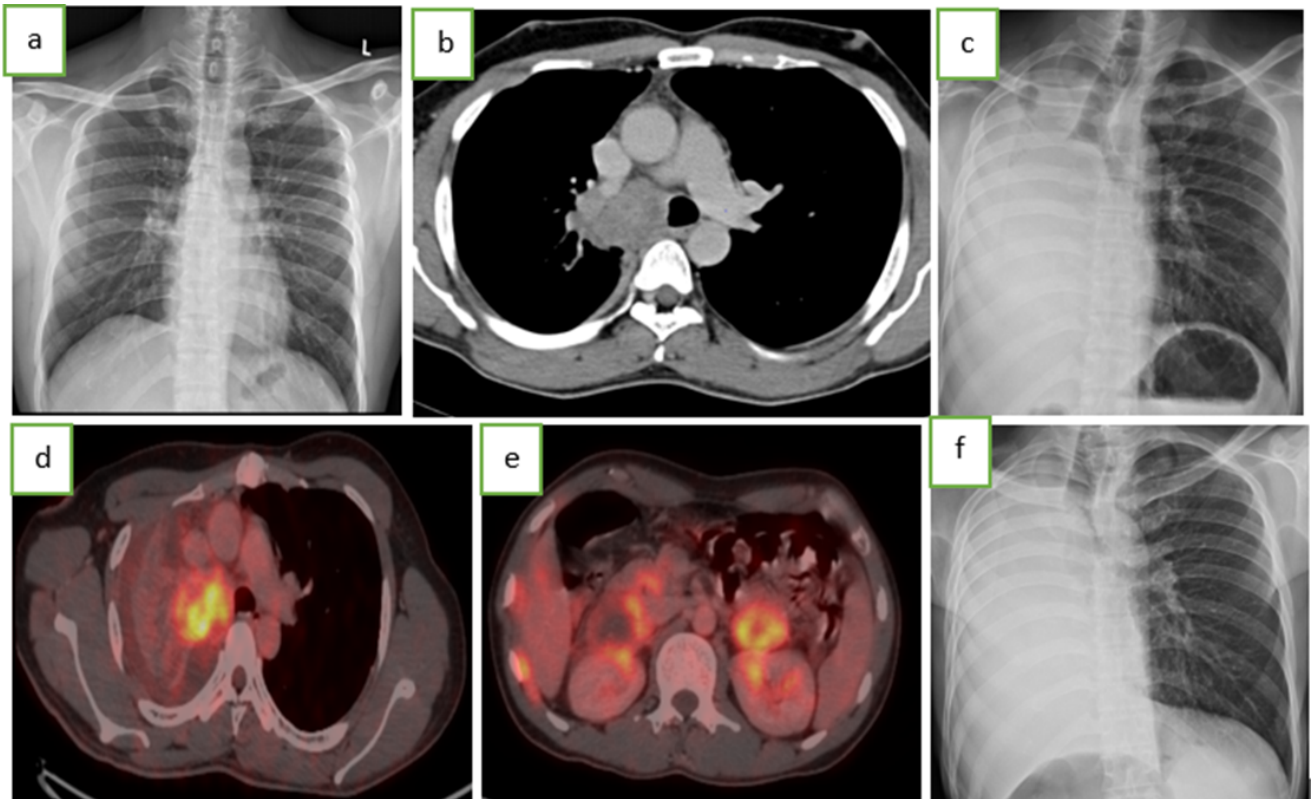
a: Chest X-ray posteroanterior view with normal lung zones in the month of February; b: A heterogeneously enhancing mass in the right hilum and right main bronchus; c: Complete right lung collapse in the month of April; d: PET-CT image shows the uptake of primary lesion involving the right main bronchus; e: PET-CT image shows multiple liver, adrenal and renal uptake suggestive of metastasis; f: Even after 8 months of chemotherapy, chest X-ray showed furthermore narrowing of trachea and left main bronchus in the month of December.
